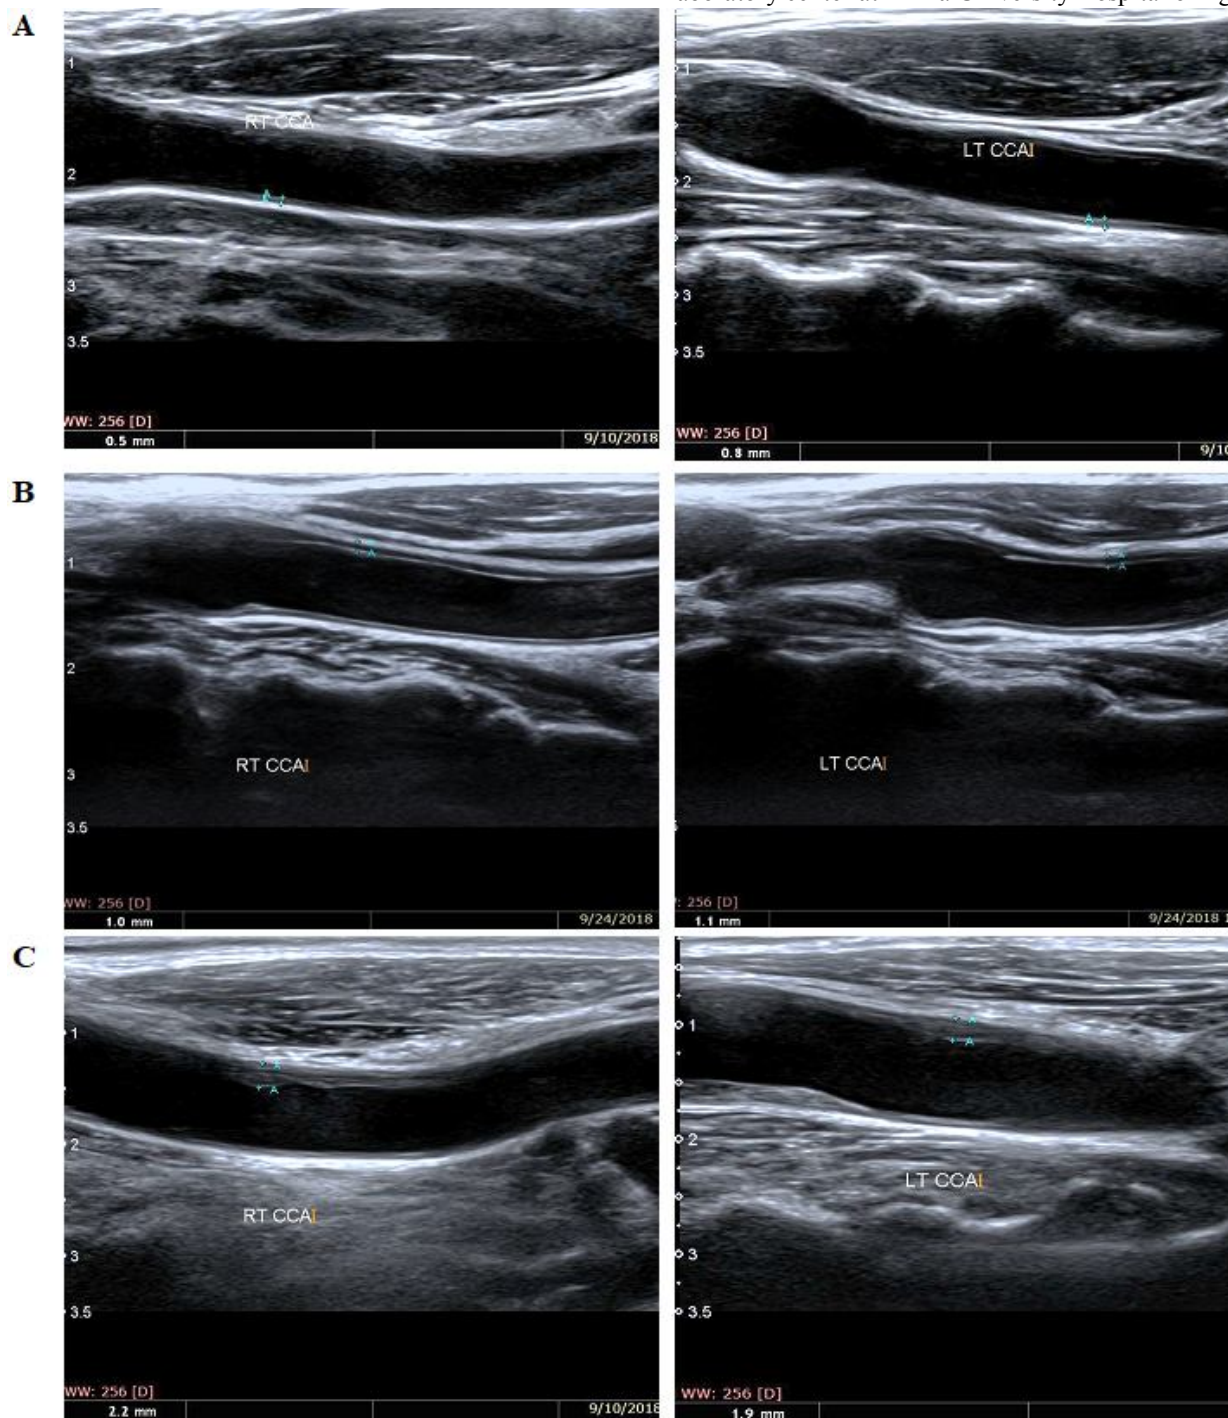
High-resolution B mode Doppler ultrasonography of common carotid artery intima media thickness (CIMT) in 3 different cases (A, B and C). A: normal right (RT) and left (LT) CIMT (< 0.9 mm). B: a case of early atherosclerotic changes (RT CIMT= 1.0 mm, LT CIMT = 1.1). C: a case of suggested established bilateral carotid arterial atherosclerotic changes (RT CIMT= 2.2 mm, LT CIMT = 1.9).
